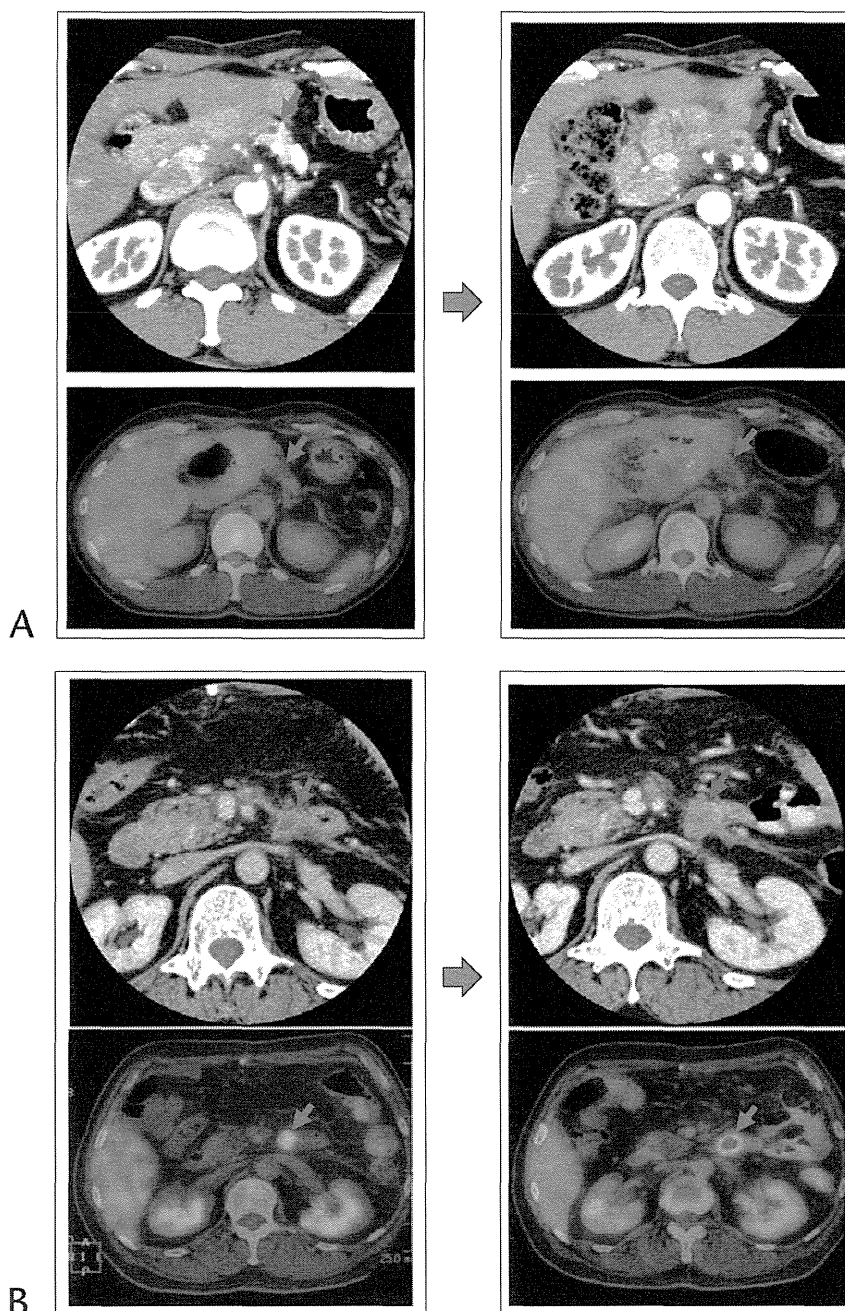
Positron emission tomography/CE-CT findings of 2 typical cases, 1 with “local recurrence” and the other with “no local recurrence,” are shown. A, A 46-year-old man with no local recurrence (false-positive by CE-CT and true-negative by PET/CE-CT). The CE-CT image, which was performed 17 months after surgery, showed a soft tissue density mass, which did not rule out local recurrence (left upper panel, arrow). However, the PET/CT image did not show FDG uptake corresponding to this mass, suggesting no local recurrence (left lower panel, arrow). A follow-up PET/CE-CT image, which was performed 8 months after the initial examination, revealed no increase in the size and FDG uptake of the mass (right panel, arrow), indicating that the initial diagnosis of no local recurrence by PET/CE-CT was correct. B, A 59-year-old man with local recurrence (true-positive by CE-CT and PET/CE-CT). The CE-CT image, which was performed 3 months after surgery, showed a soft tissue density mass, which did not rule out local recurrence (left upper panel, arrow). The PET/CT image shows abnormal FDG uptake (SUV_{max} 4.73) corresponding to this mass, suggesting local recurrence (left lower panel, arrow). A follow-up PET/CE-CT image, which was performed 3 months after the initial examination, revealed an increase in the size and FDG uptake (SUV_{max} 6.99) of the mass (right panel, arrow), indicating that the initial diagnosis of local recurrence by PET/CE-CT was correct.
